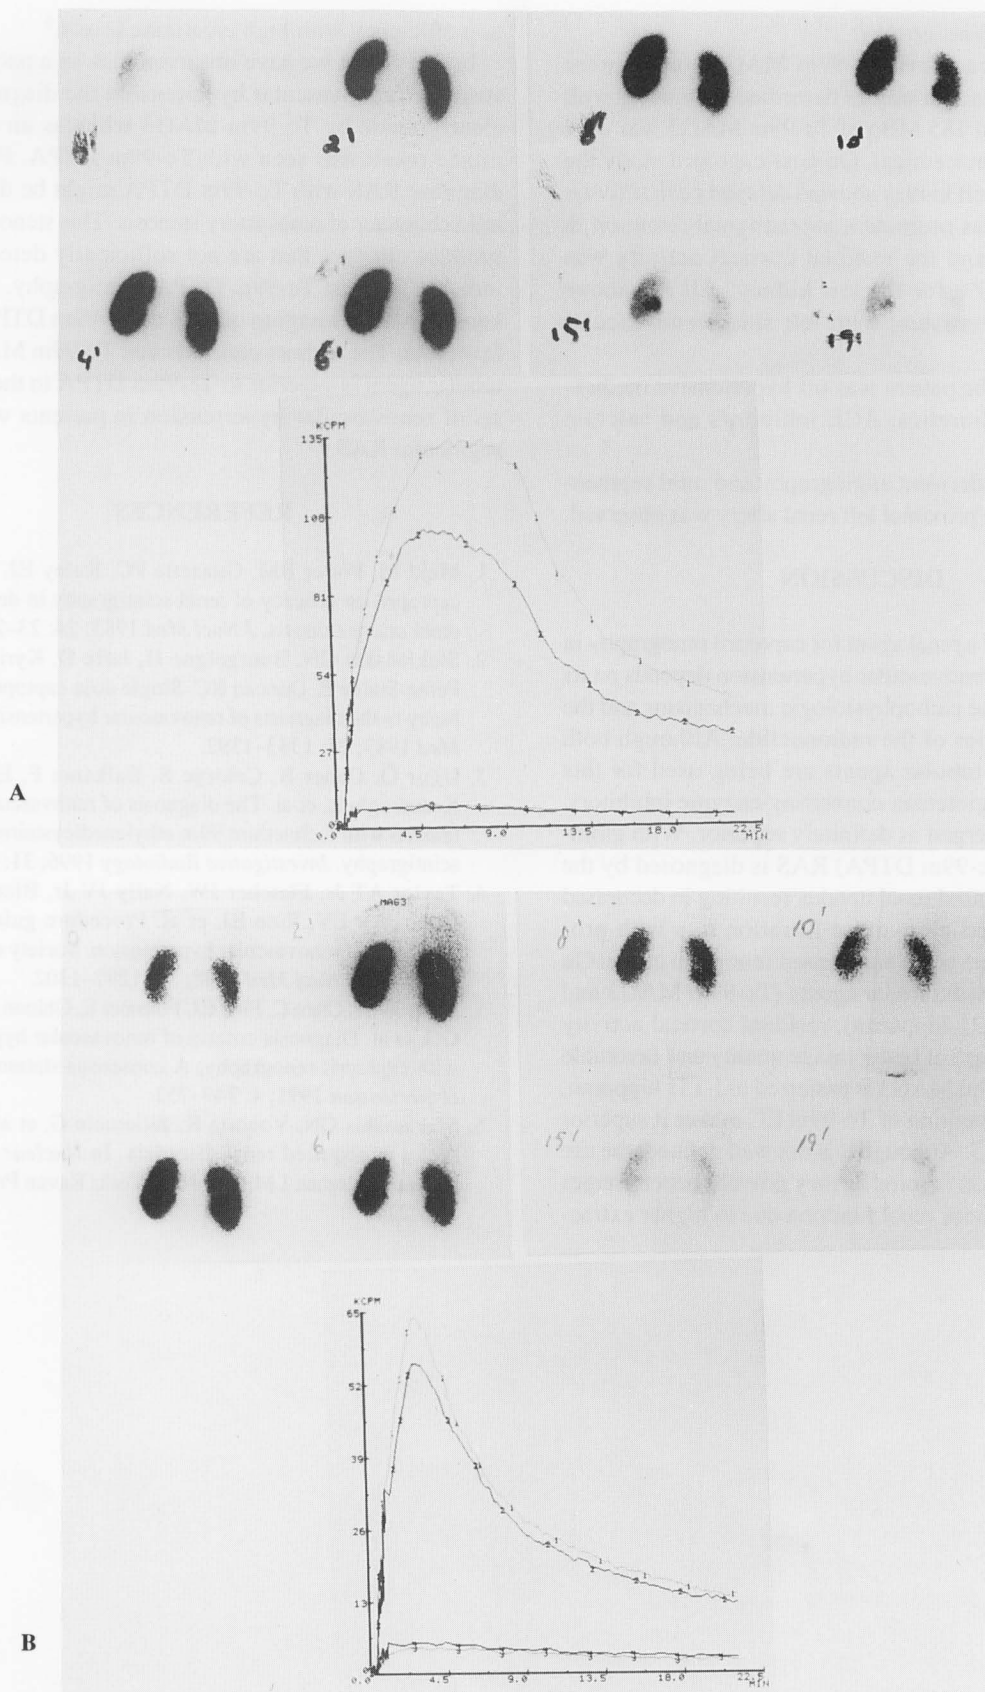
Prominent cortical retention on the left side of the Tc-99m MAG3 captopril scintigraphy (A) which was highly suggestive for the renal artery stenosis which was later confirmed by renal angiography. Bilateral symmetric functions were observed on the Tc-99m MAG3 basal scintigraphy (B).
